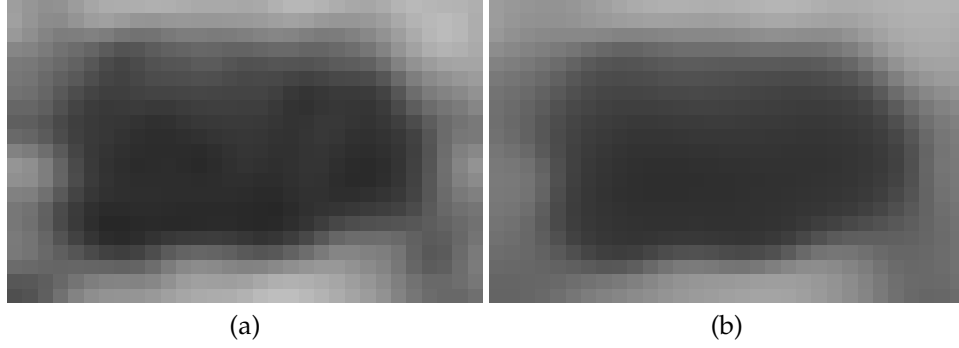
(a) Downsampling the original ultrasound image, shown in Fig. 6.2(a), by a factor of 4 in each dimension. (b) Filtering the downsampled image with a bilateral filter of size  $5 \times 5$  pixels.
